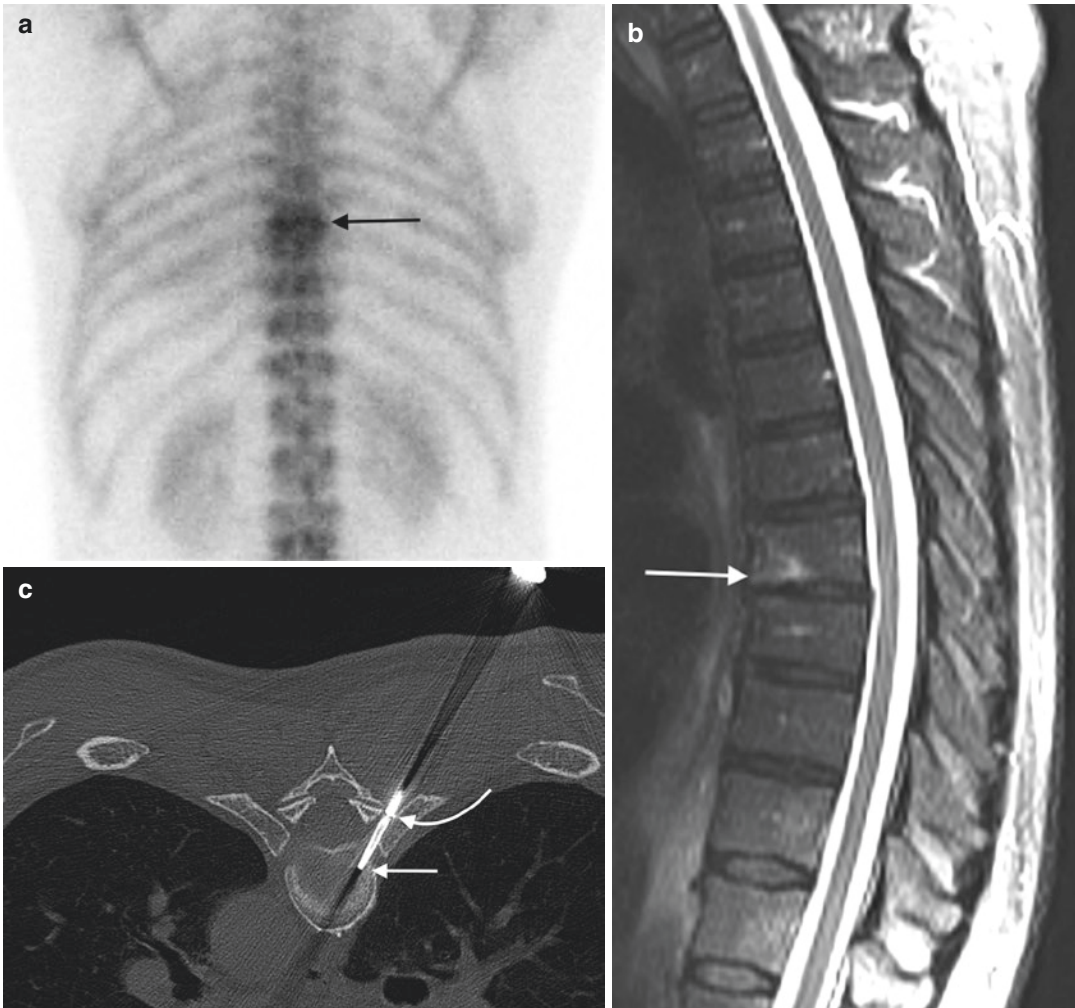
A 64-year-old male with right rib cage pain; normal WBC, ESR, and CRP. Single posterior projection (a) from a bone scan shows focal radionuclide uptake (arrow) within the mid-thoracic spine. T2-weighted sagittal image (b) shows focal hyperintense signal within the anterior vertebral body (arrow). Axial CT image (c) from the biopsy procedure shows the use of a costovertebral approach (curved needle) with coaxial insertion of a bone needle (arrow) into the disk-endplate complex. The biopsy, with respect to both pathology and microbiology, was negative
